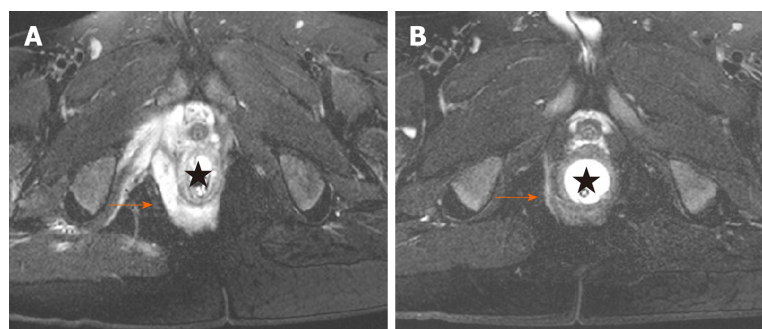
Deep remission of Crohn's disease-related perianal fistula on magnetic resonance imaging. A: Hyperintense signal on T2-weighted fat-suppression imaging showing an active suprasphincteric fistula; B: Disappearance of hyperintense signal on T2-weighted fat-suppression imaging displaying deep remission of the fistula.
